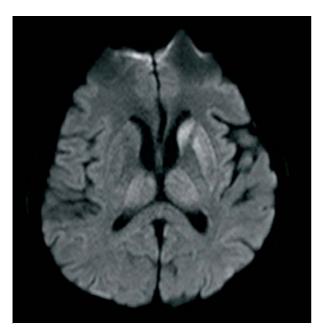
DWI-MRI sequence showing bilateral thalamus and left caudate nucleus and putamen restriction.
